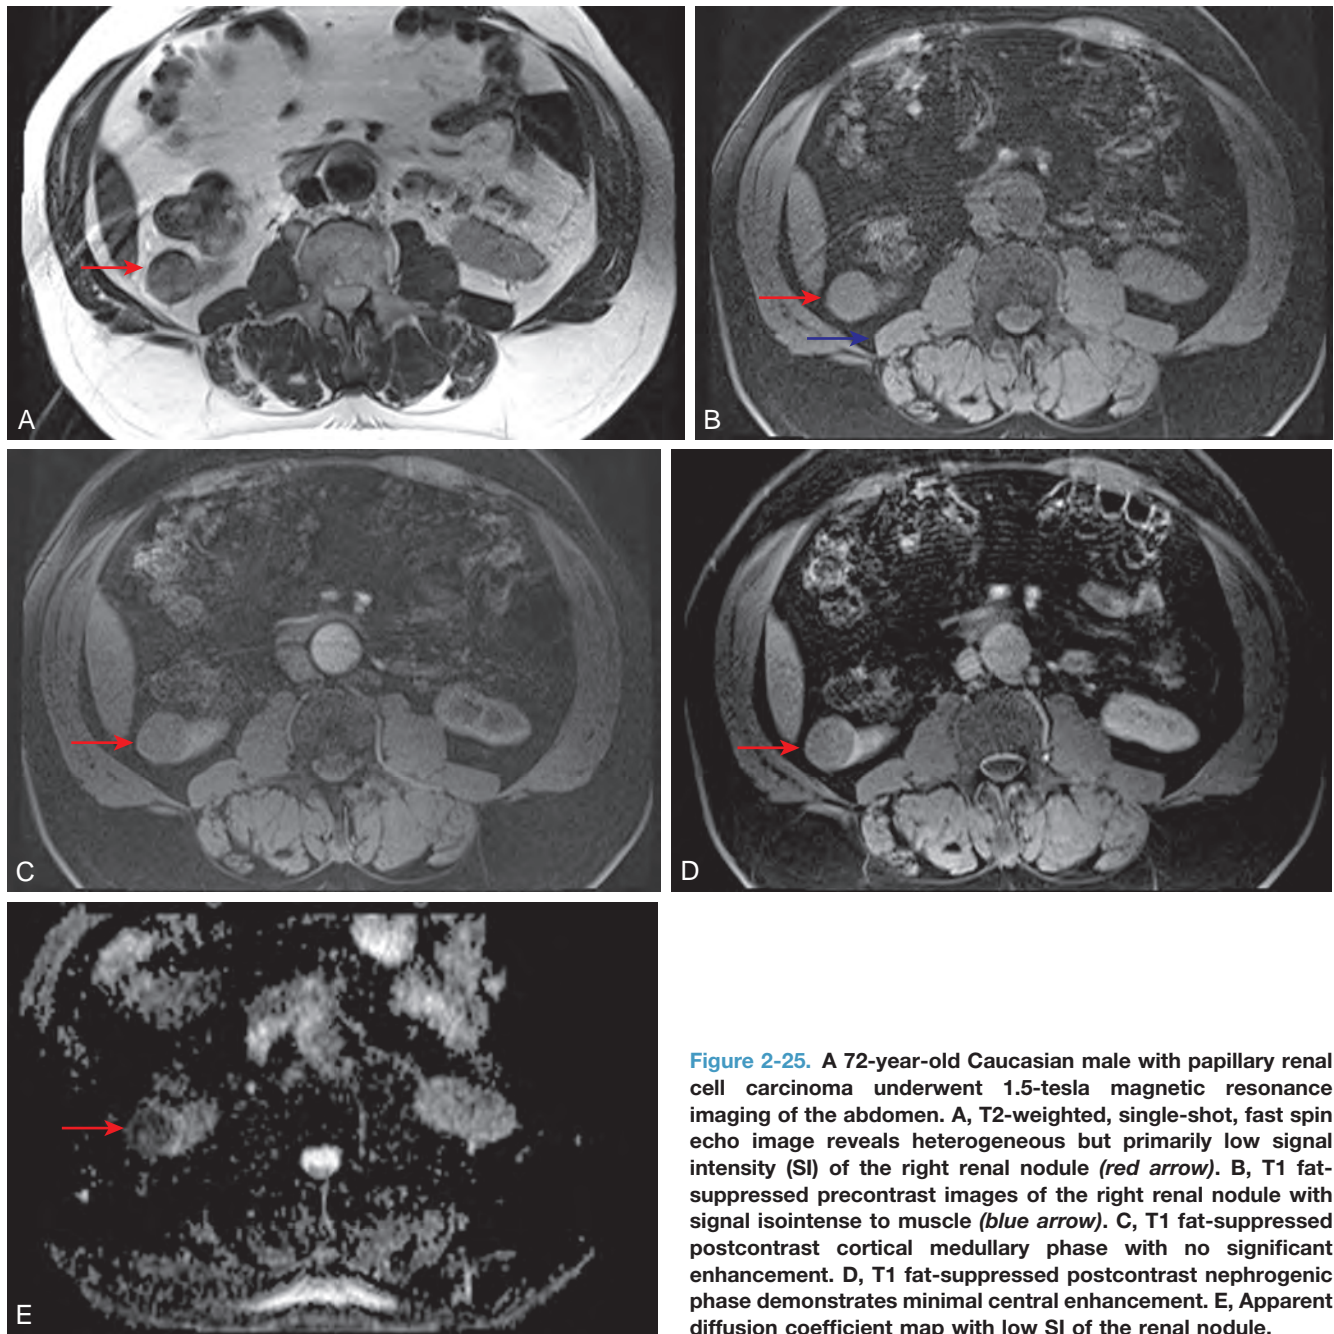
A 72-year-old Caucasian male with papillary renal cell carcinoma underwent 1.5-tesla magnetic resonance imaging of the abdomen. A, T2-weighted, single-shot, fast spin echo image reveals heterogeneous but primarily low signal intensity (SI) of the right renal nodule (*red arrow*). B, T1 fat-suppressed precontrast images of the right renal nodule with signal isointense to muscle (*blue arrow*). C, T1 fat-suppressed postcontrast cortical medullary phase with no significant enhancement. D, T1 fat-suppressed postcontrast nephrogenic phase demonstrates minimal central enhancement. E, Apparent diffusion coefficient map with low SI of the renal nodule.
